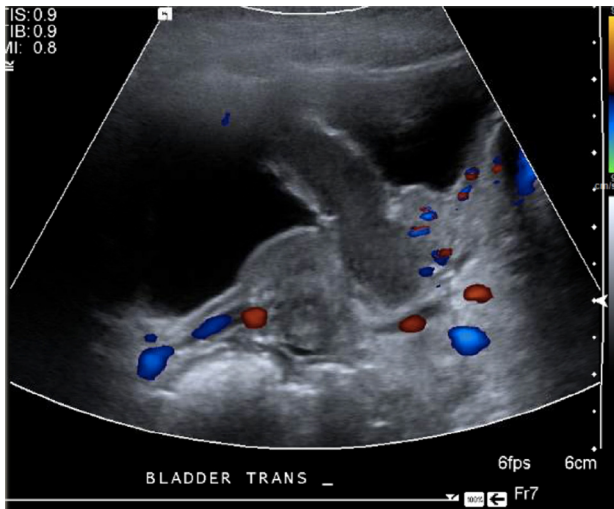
Bladder sonogram at presentation revealing a 1.0 cm diameter mass extending into the bladder at the level of the left trigone. (Color version available online.)
